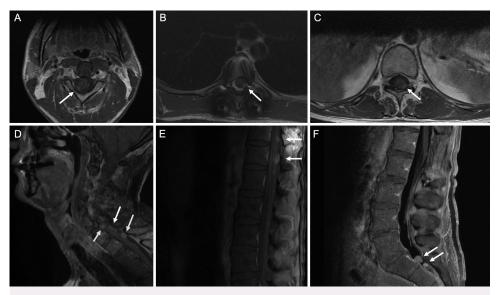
Case 1. Axial (A–C) and sagittal (D–F) T1-weighted postcontrast images at different levels demonstrating the diffuse extent of small enhancing metastatic nodules along the cord surface, as indicated by the arrows.
